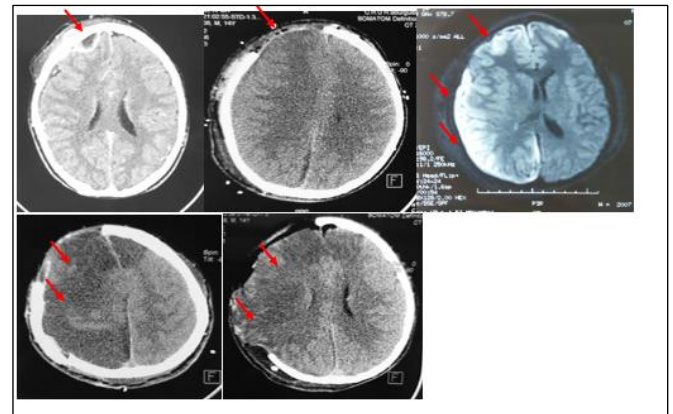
3A: right frontal swelling with osteitis; 3B: post-surgery brain CT-scan; 3C: Cerebral MRI: right hemispherical subdural collection of 5mm FLAIR hypersignal and Diffusion low apparent Diffusion Coefficient with right internal temporal engagement; 3D: development of ischemia in the right hemisphere with an increase in cerebral edema and in the midline deviation (9 vs 7 mm); 3E: post-surgery brain CT-scan. .
